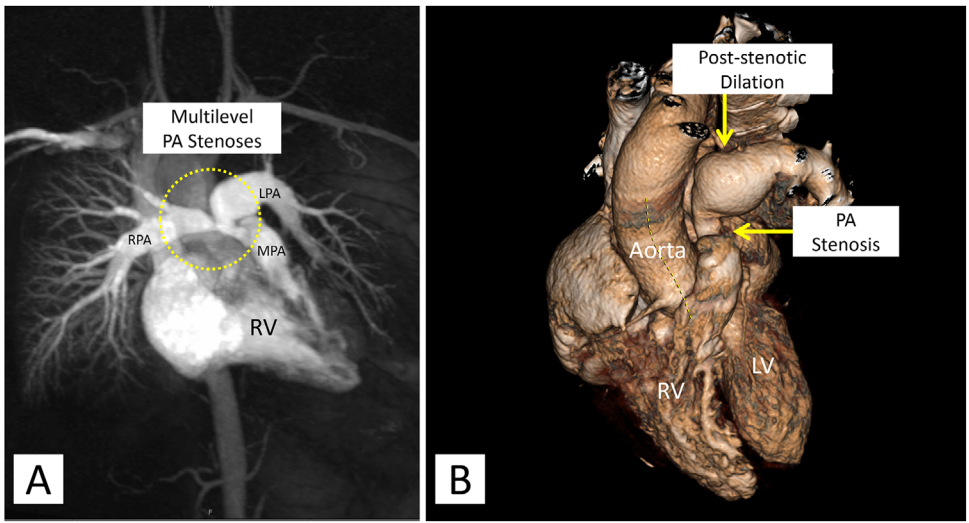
Multilevel pulmonic stenosis Panel A: Contrast-enhanced chest CT shows significant stenosis of the pulmonary valve and origin of the left pulmonary artery (dashed circle). Panel B: Posterior sagittal 3D reformatted image from the same exam shows pulmonary artery stenosis and post-stenotic dilation of the left pulmonary artery. LPA, left pulmonary artery; LV, left ventricle; MPA, main pulmonary artery; RPA, right pulmonary artery; RV, right ventricle.
